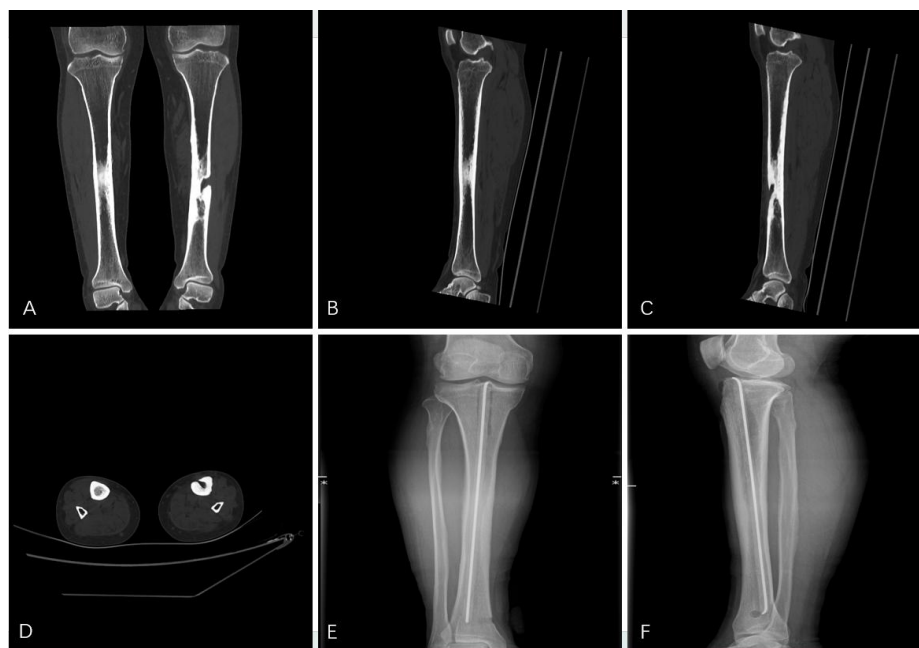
A: CT 3D reconstruction in coronal position; B: CT 3D reconstruction in sagittal position (R); C: CT 3D reconstruction in sagittal position (L) D: CT 3D reconstruction in axial position; E: X-ray postoperative orthopantograph; F: X-ray postoperative lateral position
